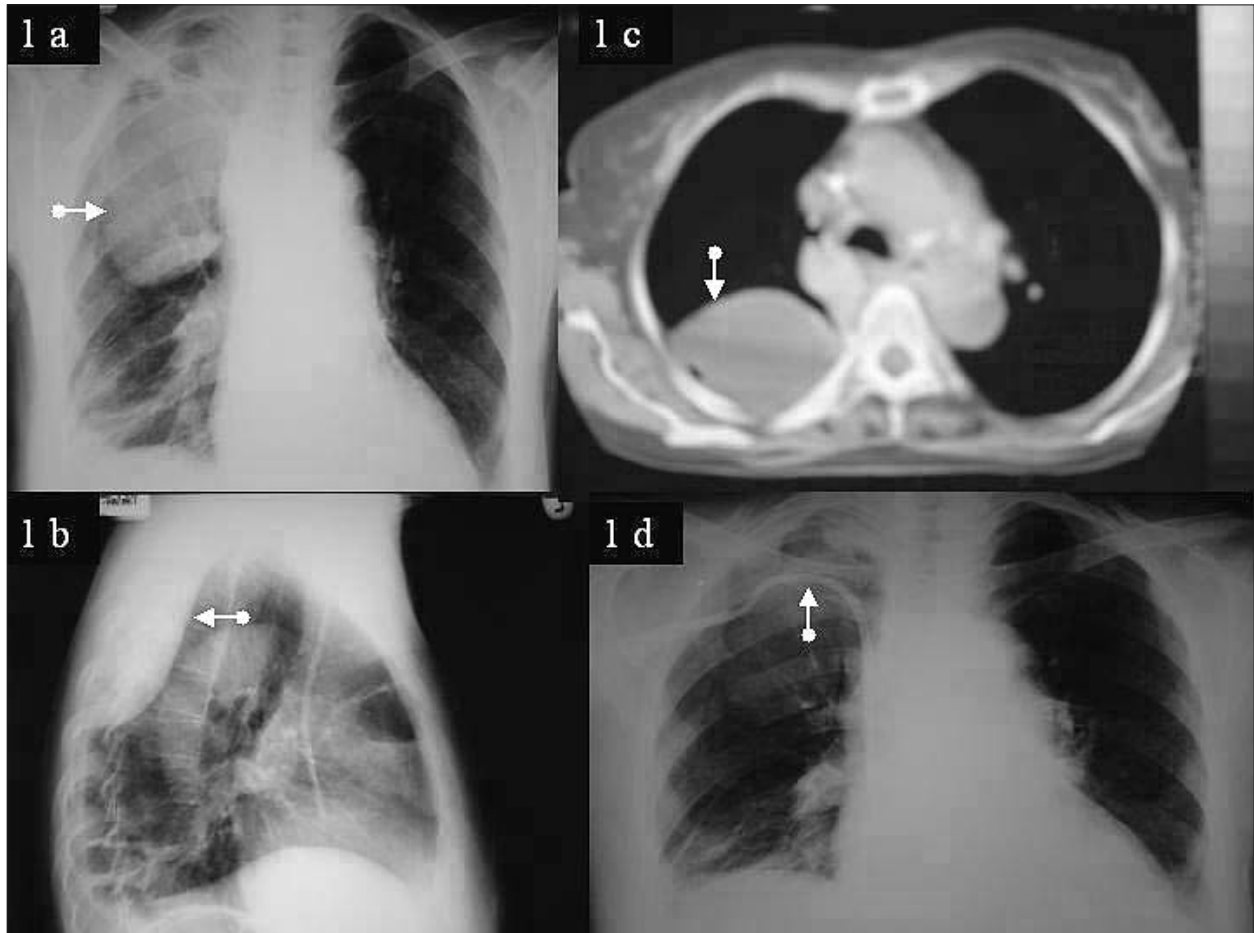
a-d. - Patient 1. (a) Postero-anterior chest roentgenogram revealing an intense, round, homogeneous shadow, 6x5 cm, in the upper zone (arrow). (b) Lateral chest roentgenogram showing a 7x4 cm intense, homogeneous density, with a broad basis arising from the chest wall, situated near the vertebral column (arrow). (c) Chest CT demonstrating a loculated extrapleural effusion in the right hemithorax (arrow). (d) Follow-up chest X-ray revealing no evidence of any residual disease. A catheter is present in the right subclavian vein (arrow).
